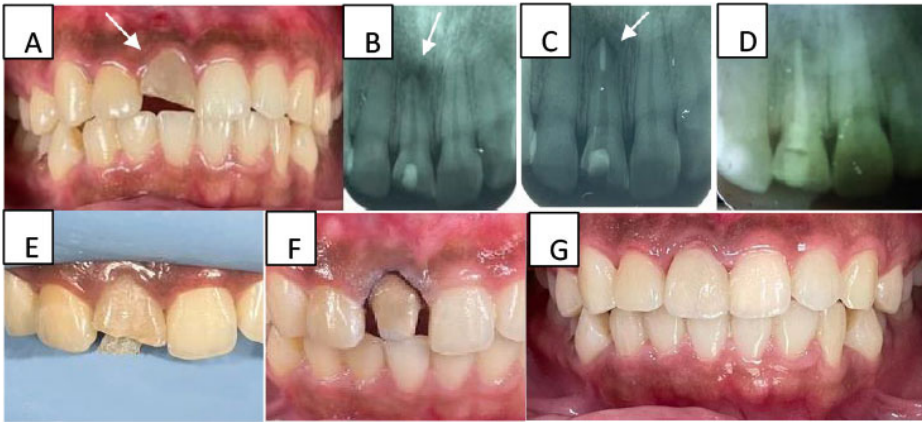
A. preoperative intraoral of #11 with crown fractured and grayish discoloration; B. preoperative radiograph showed #11 open apex and periapical radiolucency; C. 3 mm of MTA placed on 1/3 apical third of #11; D. thermoplasticized obturation of #11; E. custom fiber post insertion on #11; F. crown preparation for PFZ; G. postoperative intraoral.
